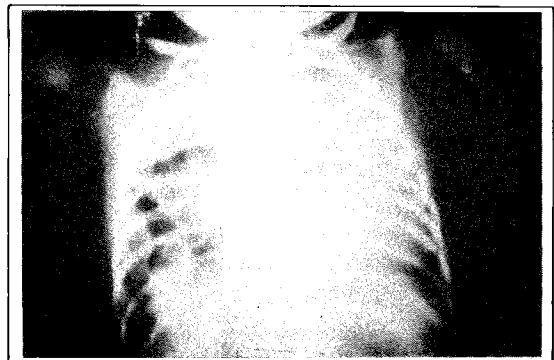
Radiography soon after birth shows air-filled viscera in the right hemithorax, with deviation of the mediastinum (note the stomach tube and the endotracheal tube) and crowding out of the opposite hemithorax. The bubble of air below the diaphragm shows an erect intra-abdominal stomach.
